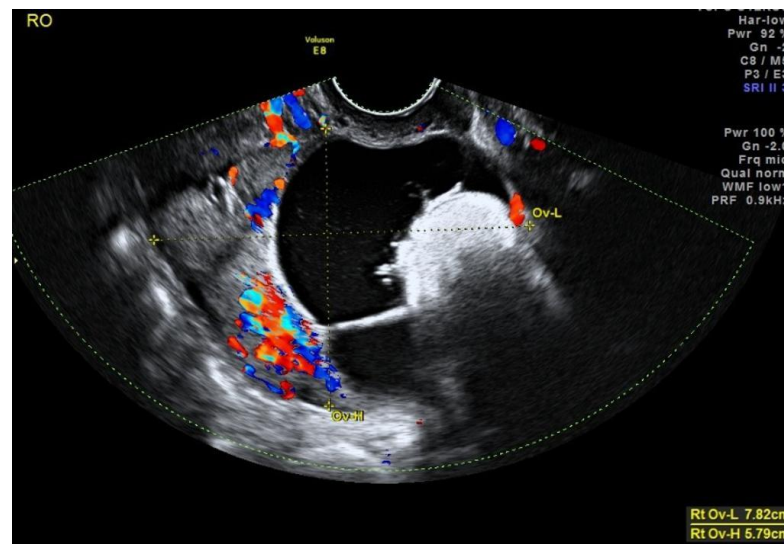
Ultrasound picture of dermoid cyst showing the "tip of the iceberg" sign (Beller, 1998).
